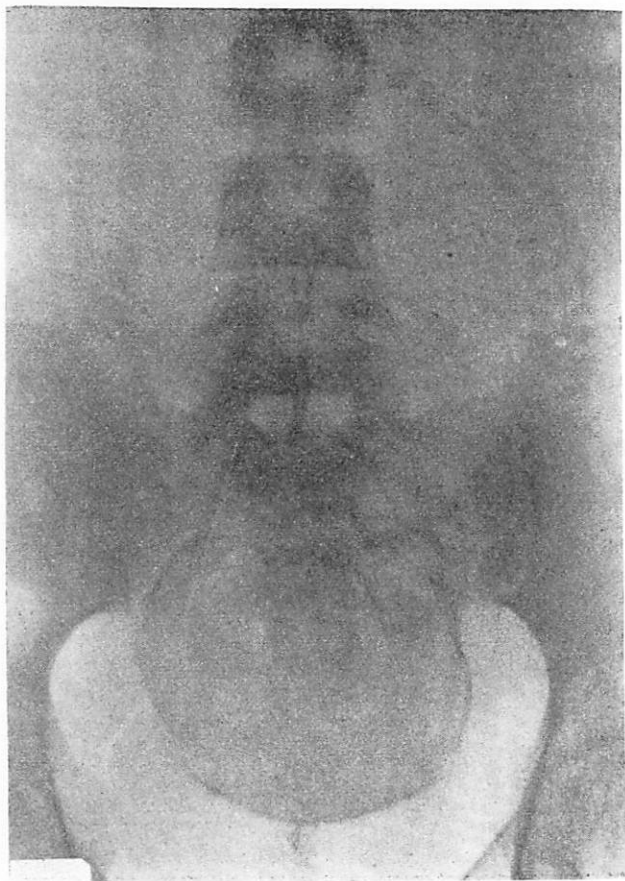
Mrs. M. B., No. 5164. Eight and one-half months pregnant. Examined in prenatal clinic May 9, 1930. Fetal heart O. K. Fetal movement present. Admitted to Methodist Episcopal Hospital May 12, 1930, fetal heart not heard, no fetal movements for two days. Roentgenogram showed distinct overlapping of skull bones and bowing of spine. Stillbirth two days later. Diagnosis of fetal death made by the roentgenologist between forty-eight and seventy-two hours after fetus died. Earliest case in our records.
